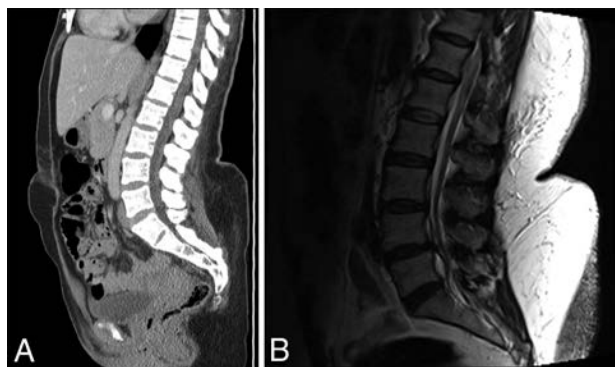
Adult female patients with morbid obesity and large fat shelf on the lower lumbar back. *A*, Sagittal reformation from a noncontrast abdominal and pelvis CT shows the deformity of the back, even with the patient supine. *B*, Sagittal T2 MR image in another patient with marked subcutaneous fat in the lower thoracic and lumbar back. Note an abrupt increase in fat thickness at the L3 level, which makes LP difficult.
